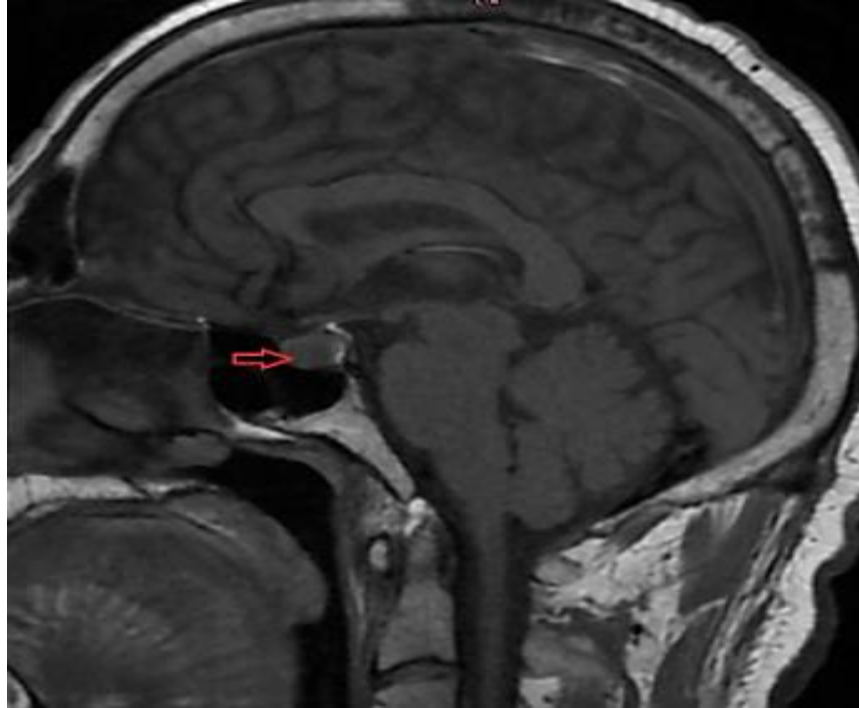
Sagittal brain MRI of the sellar region demonstrating a pituitary macroadenoma (15×7.7×9mm) (arrow).
